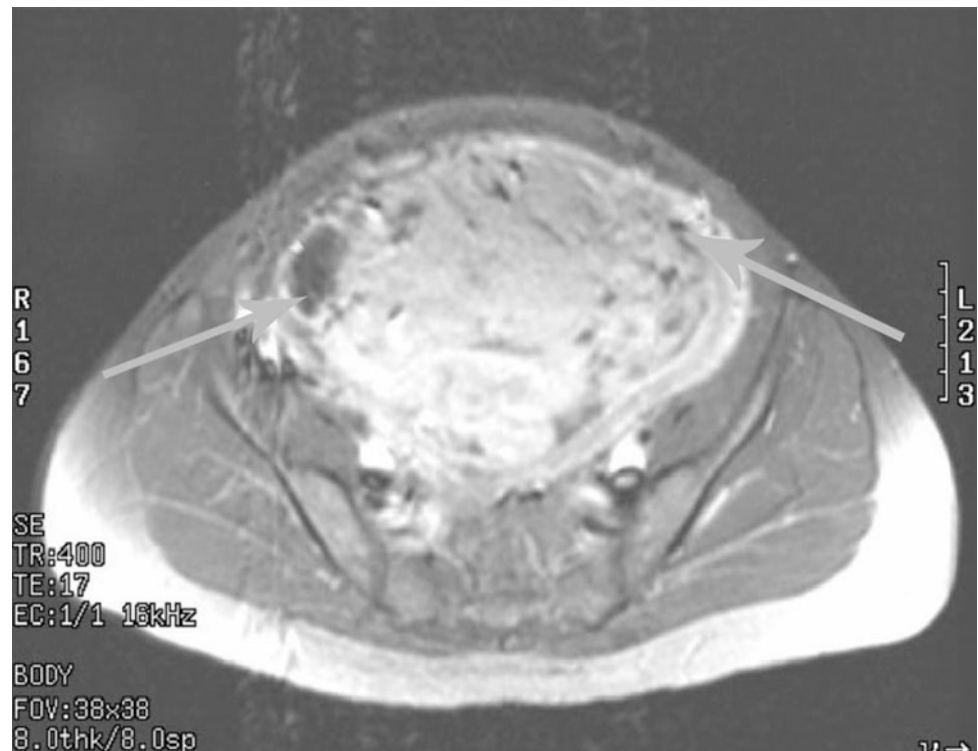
Postembolization MRI showing normal air pattern in uterus
